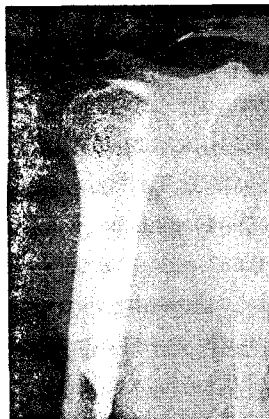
Original X-ray 1
